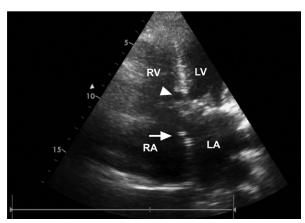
Postoperative transthoracic echocardiogram (4-chamber view) shows the pericardial patch in the atrial septum (arrow) and the closed interventricular septum (arrowhead).
